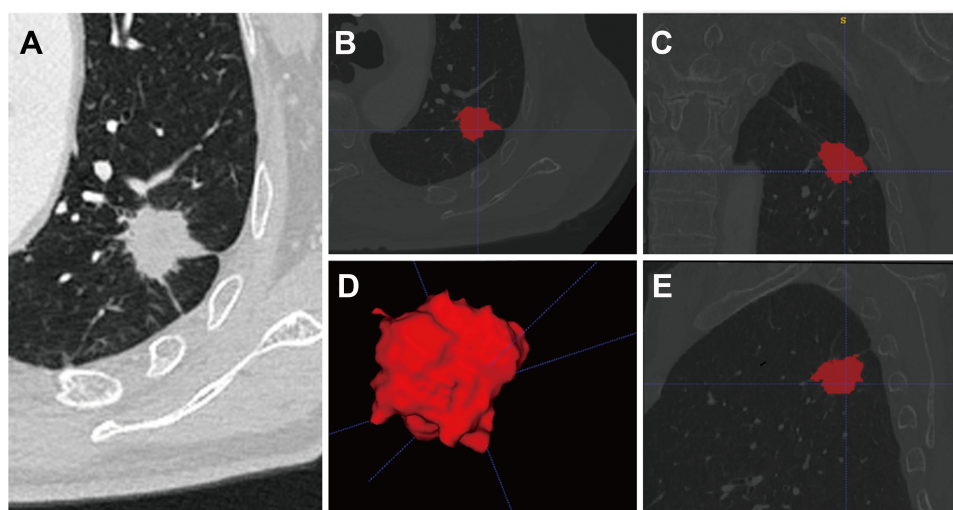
Lung adenocarcinoma in the apicoposterior segment of the left upper lobe with nodal involvement (N2). (A) Axial thin-slice CT image. (B–E) Image segmentation and texture processing (B axial view, C coronal view, D volume rendering, E sagittal view). TV, Avg, mean, skewness, and entropy values for this lesion were 5.4 cm³, 12 HU, 142.19, -0.02, and 2.03, respectively.
